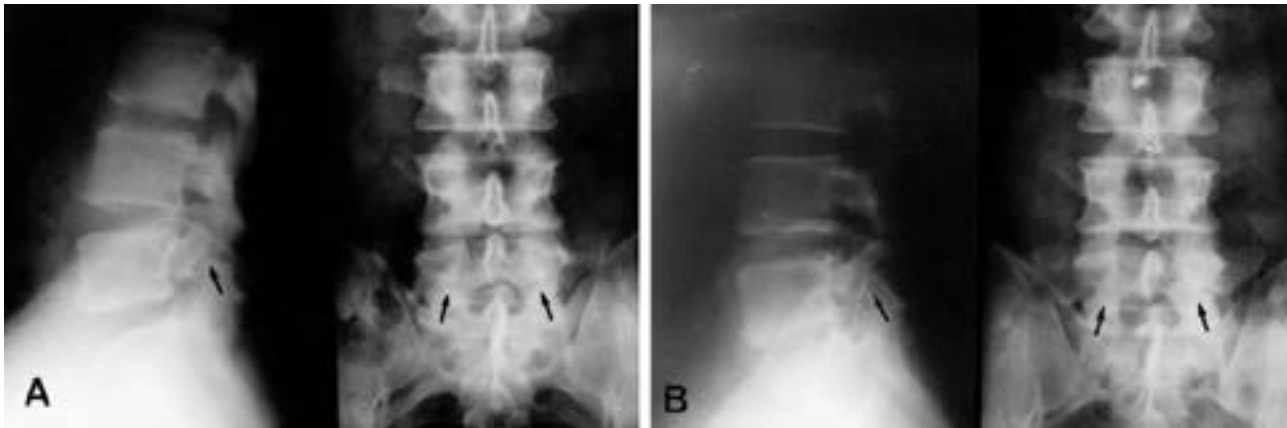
Plane radiographs of 49 year-old man with herniated intervertebral disc at L4-5 and L5-S1 and spondylosis at L5 show well demarcated pars interarticularis defect (arrow head).
